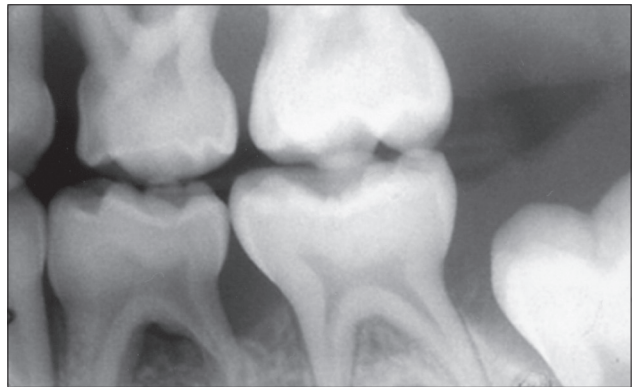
Bite-wing radiograph of the area shown in Figure 3a. Generalized periodontitis affecting the primary teeth is clear.
